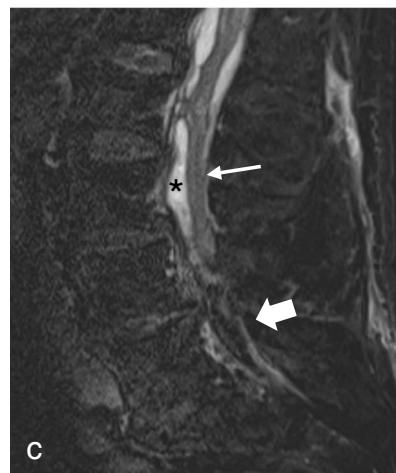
(a) T1, T2 Dixon (b) fat only and (c) water, and (d) T1 Dixon water only after intravenous contrast injection, show a heterogeneous formation with fat component at L4–L5 level (thick arrow in a–c) and another component at L3–L4 level showing high signal intensity and thin internal septa on water sensitive image (asterisk in c), higher signal intensity on T1-weighted images compared to CSF (asterisk in a), thin hypointense peripheral rim (arrowheads in a) and peripheral enhancement after intravenous contrast injection (arrowheads in d) corresponding to granulation tissue
